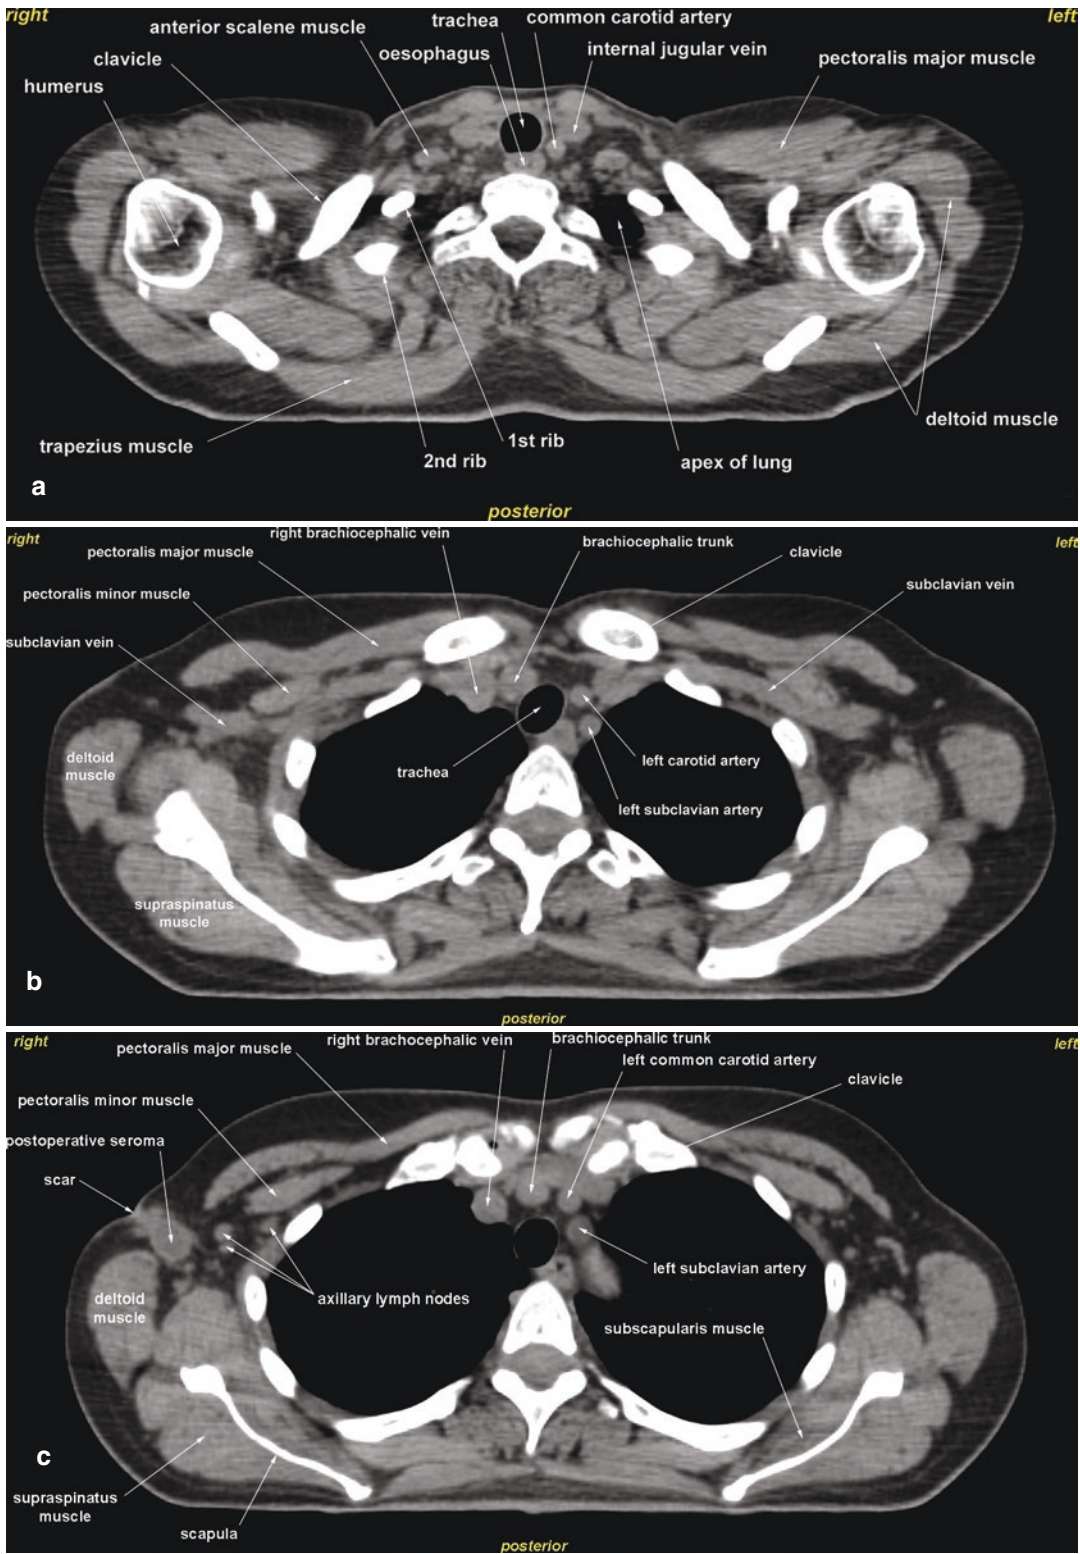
Axial non-contrast CT scans at different levels of the thorax. (a) Level of the superior thoracic aperture. (b) Level of the subclavian vessels. (c) Level of the centre of axilla. (d) Level of the aortic arch. (e) Level of the nipple. (f) Level of the apex of the heart
